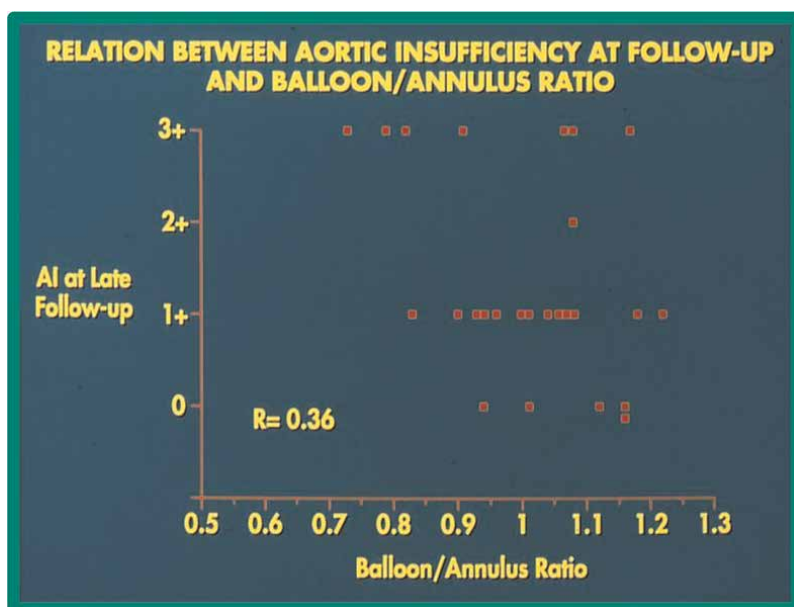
Relationship of balloon/annulus ratio utilized during balloon aortic valvuloplasty (BAV) with the degree of Doppler-assessed aortic insufficiency (AI) at late follow-up. Note poor correlation ($R = 0.36$) between these two parameters. Also note grade 3+ AI occurred with wide range of balloon/annulus ratios. (Modified from reference [7]).
